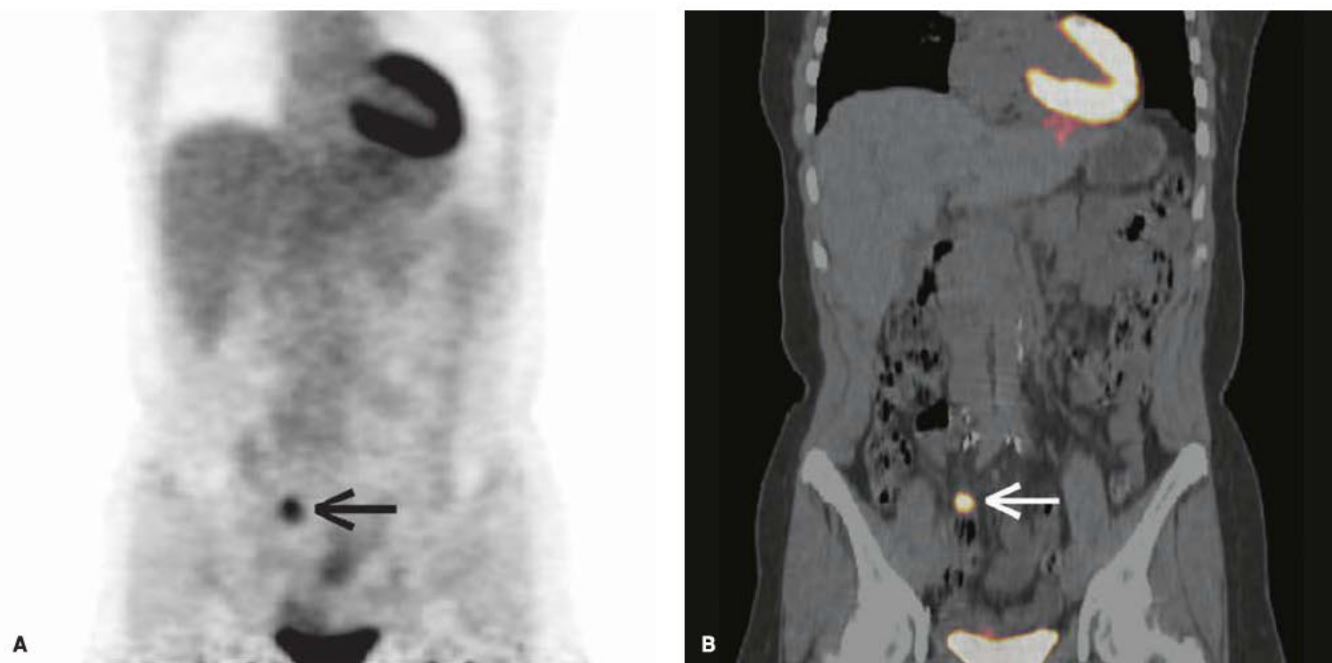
Positron emission tomography (PET) (A) and PET-computed tomography (PET-CT) fusion (B) images of a woman with recurrence of ovarian cancer. Arrows demarcate abnormal uptake of tracer in the pelvis that represented a 1-cm lymph node. The biopsy of this lymph node revealed recurrent ovarian cancer. (Reproduced with permission from Dr. Dana Mathews.)
